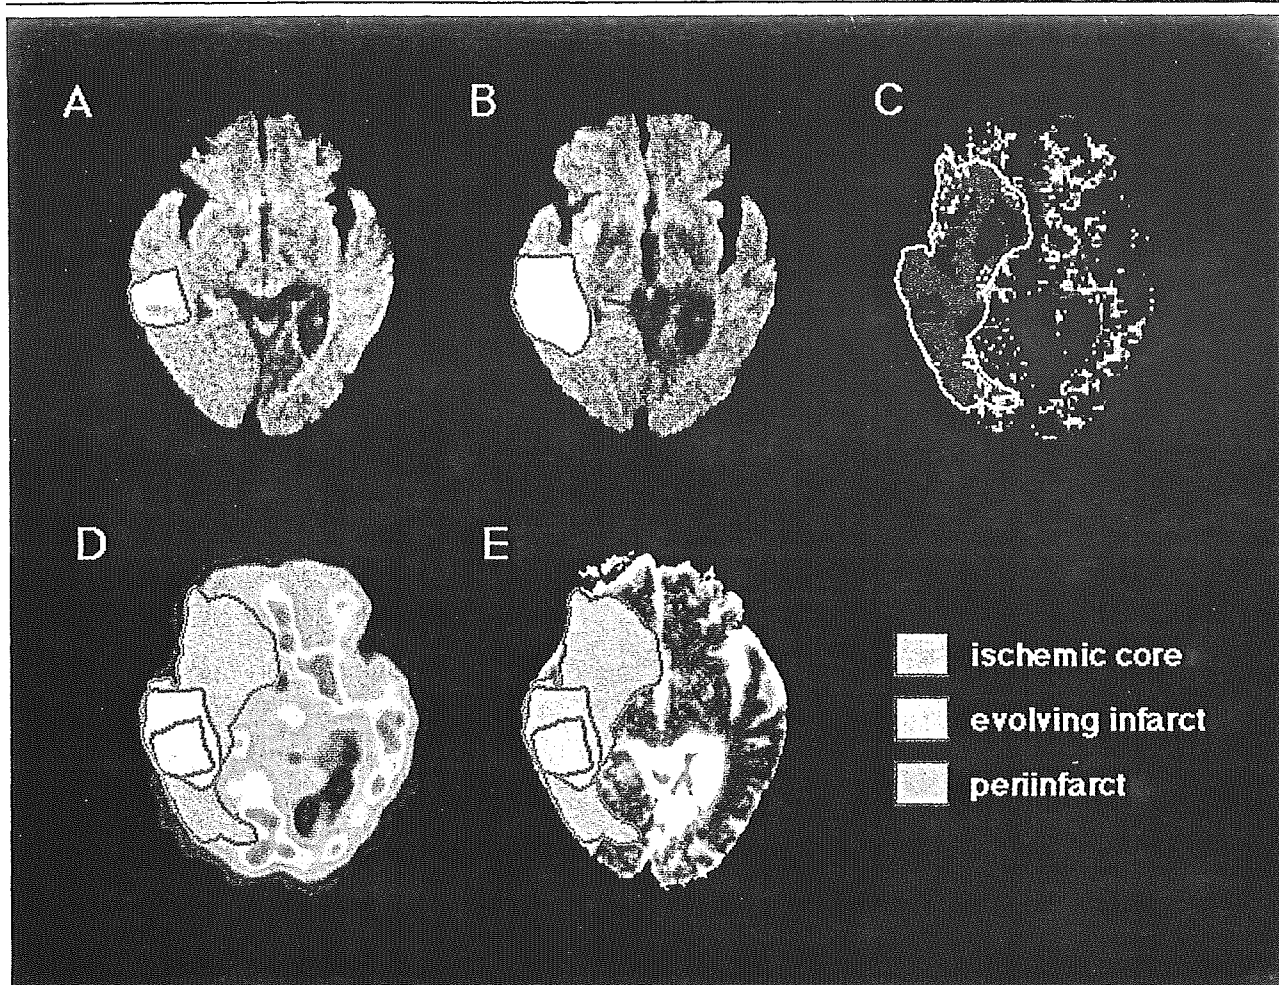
Application of regions of interest (ROIs) on ischemic core, evolving infarct, and perinfarct. All PET and ADC images are registered to T<sub>2</sub>WI obtained at day 3, and the corresponding four slice levels to PWI is selected for analysis. The ROIs of ischemic core, perinfarct, and evolving infarct are manually drawn on (A) the initial DWI within 6 hours after onset, (B) DWI performed at day 3, and (C) PWI obtained at the time of initial DWI. The ROIs are automatically superimposed on the corresponding (D) PET and (E) ADC images and are mirrored to the contralateral unaffected hemisphere.
